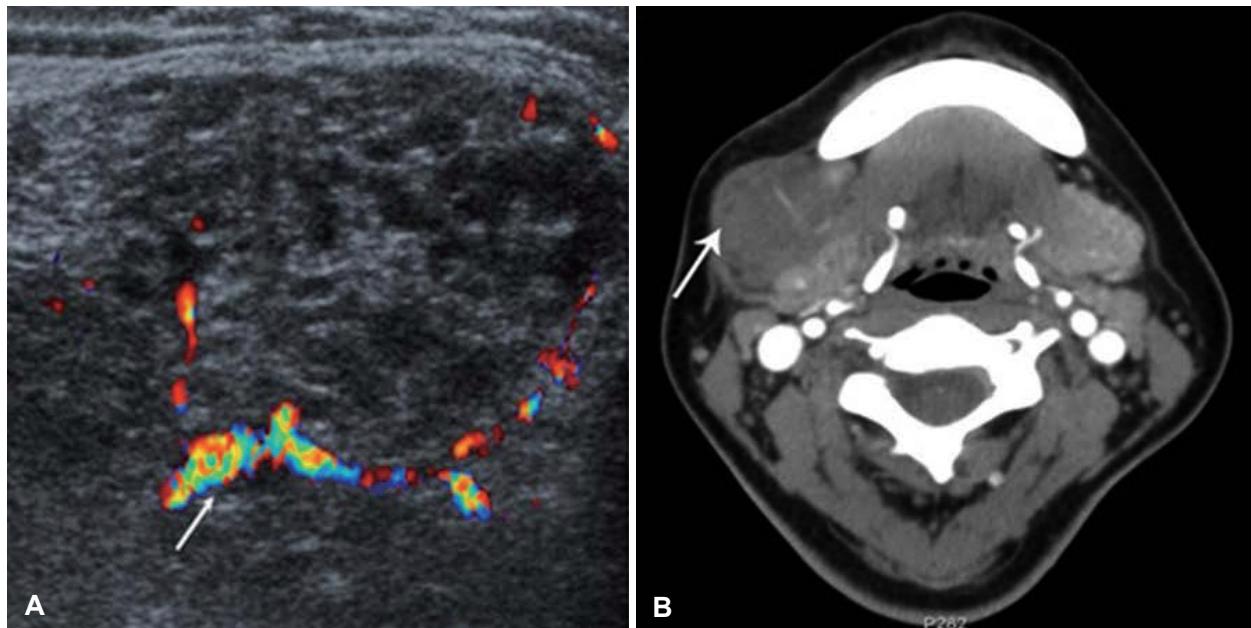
Doppler ultrasonography showing a well-circumscribed hypoechoic heterogeneous mass (arrow) with color flow in the right submandibular gland (A). Axial contrast-enhanced CT scan showing a minimally enhanced, enlarged submandibular gland (arrow) (B).
